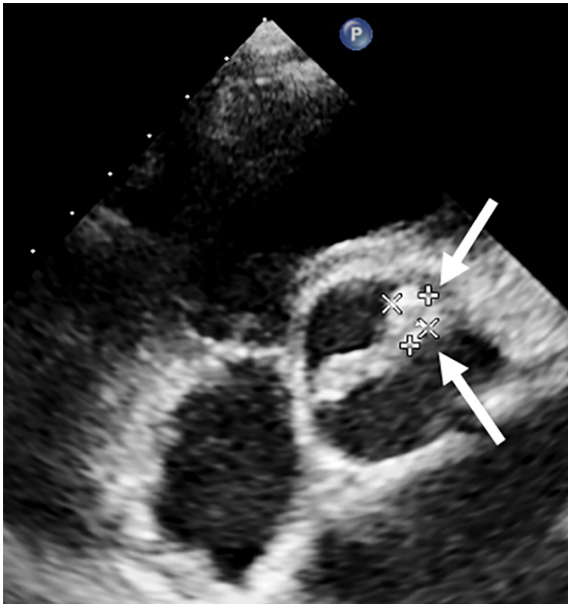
Transthoracic echocardiogram short axis view at the level of aortic valve showing a mass accepted as a vegetation attached to the aortic valve right coronary cusp. White arrows indicating the vegetation attached to the aortic valve right coronary cusp.
